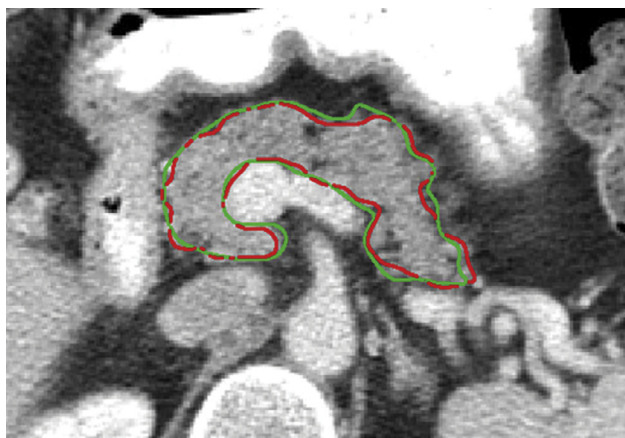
Comparison of automated pancreas segmentation (red) with manual tracing (green) on CT of a 62-year-old woman. The pancreas is relatively well-delineated by peripancreatic fat. There is mild to moderate heterogeneity of intrapancreatic CT attenuation due to islands of fat. DSC = 0.81. Standard deviation of pancreatic attenuation = 49.7 HU. Average attenuation of pancreatic neighborhood = 21.7 HU. (Color version of figure is available online.)
